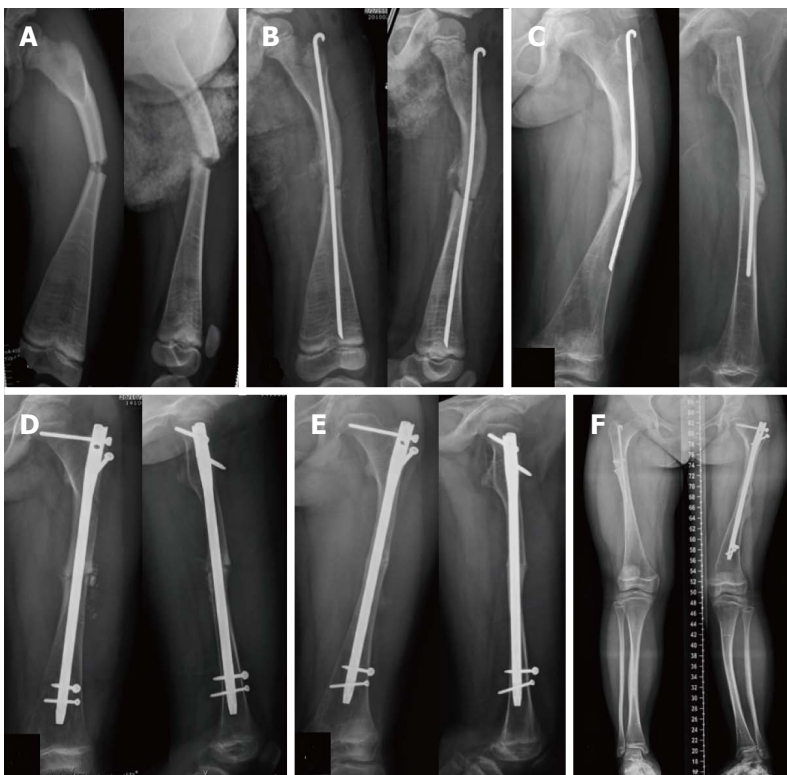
Clinical presentation of case 2. A 12-year-old girl with type III osteogenesis imperfecta presented with limping and pain on full weight bearing after Rush pin fixation for 4 years. Plain radiographs in anteroposterior and lateral views after injury (A), immediately after Rush pin fixation (B), 4 years after Rush pin fixation (C), immediately after humeral nail fixation (D), 9 mo after humeral nail fixation (E), and 1-year postoperative scanogram after humeral nail fixation (F).
